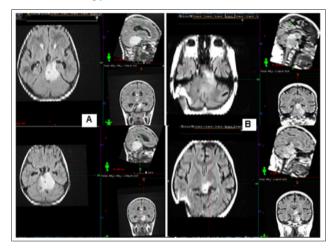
Comparison of MRI images a/ before combined with Temodal radiotherapy and in/ 2 months after the completion of the Temodal radiation treatment, followed by 2 separate courses of Temodal.
